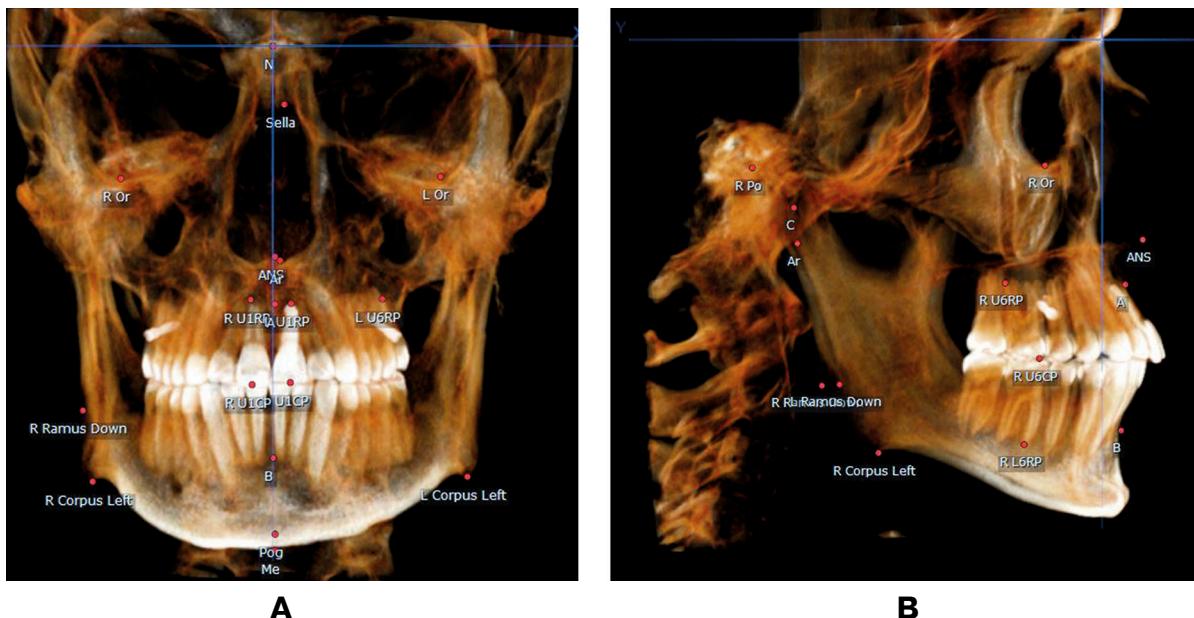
Cephalometric radiograph in frontal (A) and lateral (B) views of a child after the eruption of the second permanent molars
